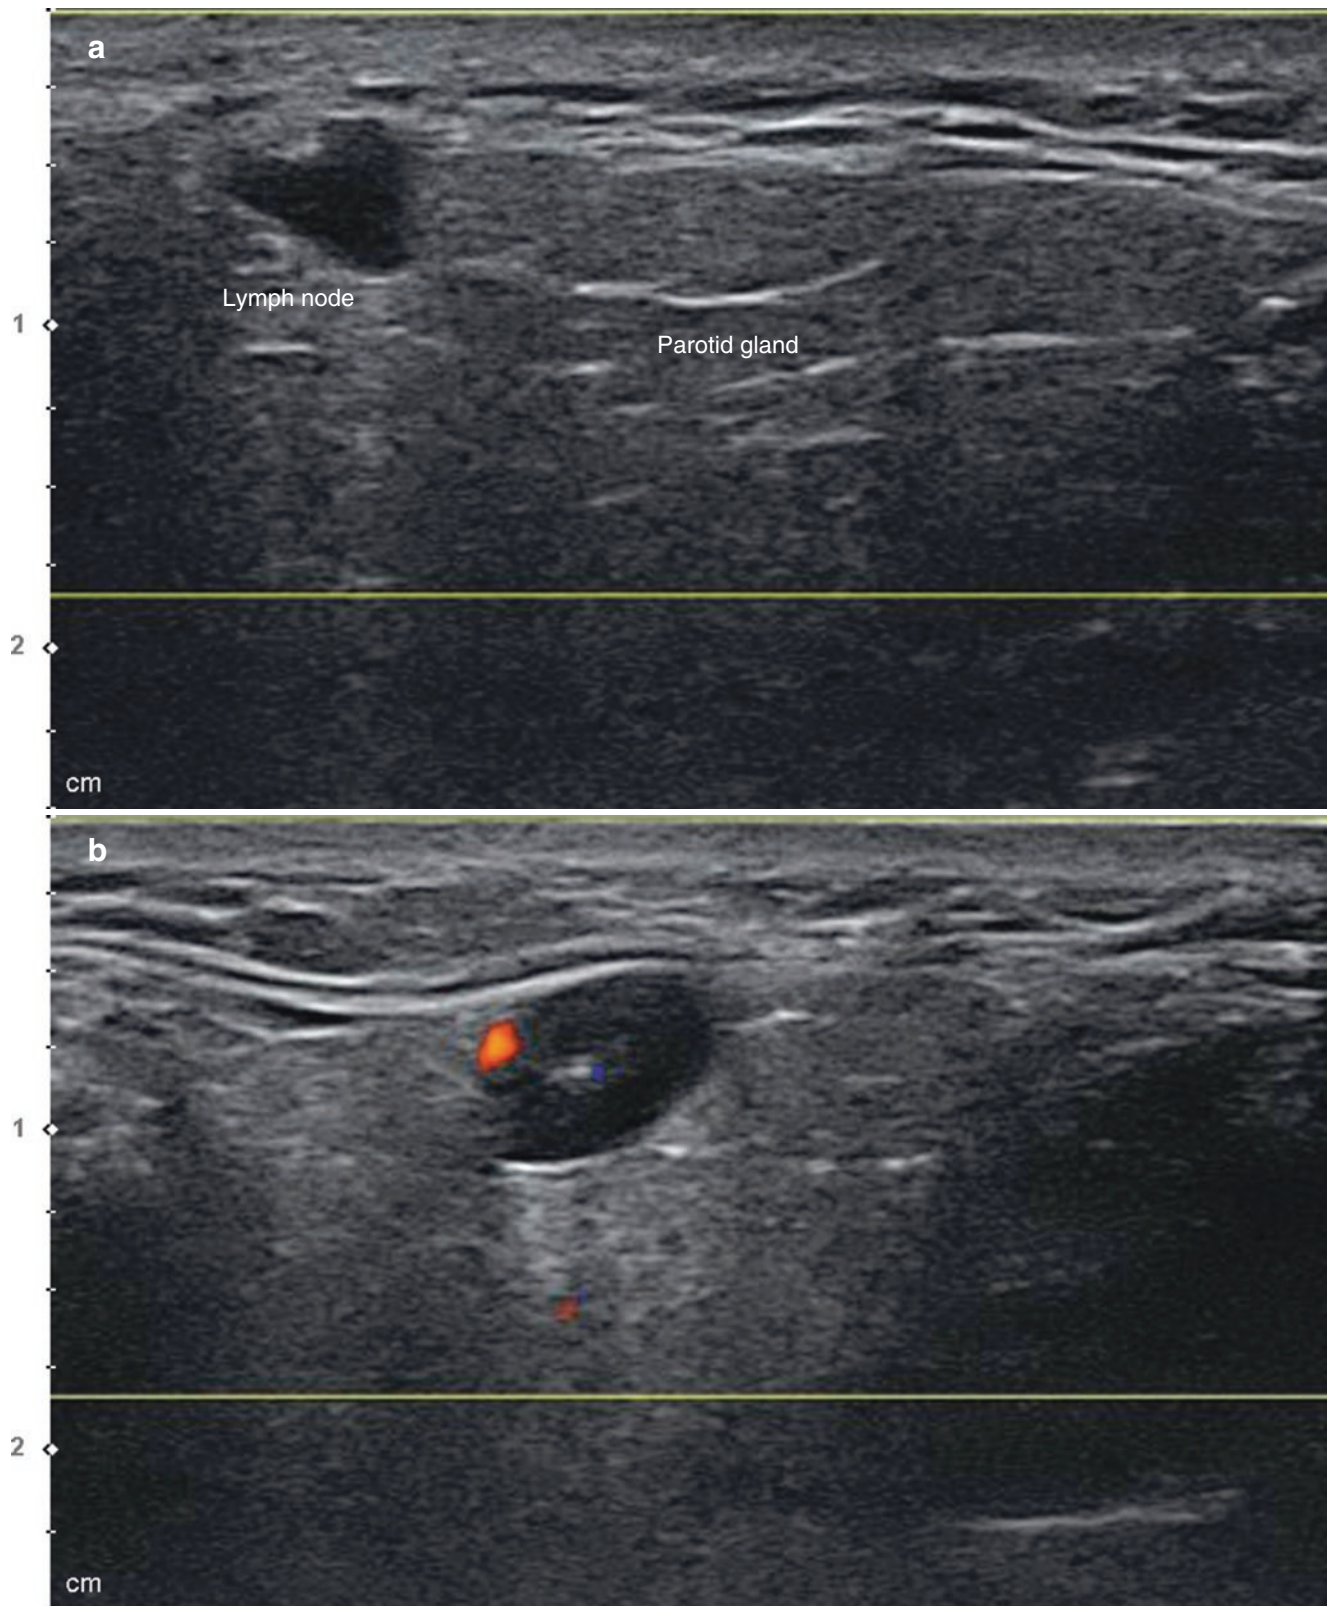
Ultrasonography of the parotid gland and parotid lymph node. (a, b) Doppler mode (transverse view, 15 MHz by linear transducer). (Published with kind permission of © Ji-Soo Kim 2020. All Rights Reserved)
